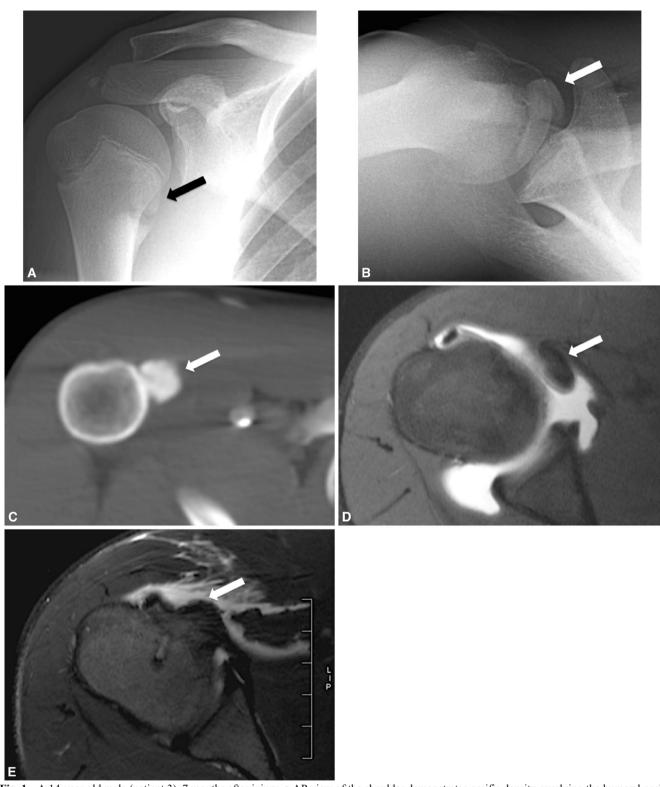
A 14-year old male (patient 3), 7 months after injury. a AP view of the shoulder demonstrates ossific density overlying the humeral neck and extending off the bone, thought to represent an osteochondroma and referred to us by an outside institution. b Axillary view of the right shoulder shows a triangular osseous structure lies anterior to the humeral neck which represents the lesser tuberosity avulsion (*arrow*). c CT image at the level just below the lesser tuberosity demonstrates the fragment anteromedial along the humeral neck (*arrow*). d T1-weighted fat suppressed axial MR arthrogram at the inferior aspect of the glenohumeral joint demonstrates the lesser tuberosity avulsion fragment attached to the subscapularis tendon (*arrow*). e Axial T2-weighted image from an MR arthrogram obtained after surgery shows the repaired tendon attaching to the area of the lesser tuberosity with a biosabsorbable anchor (*arrow*).
